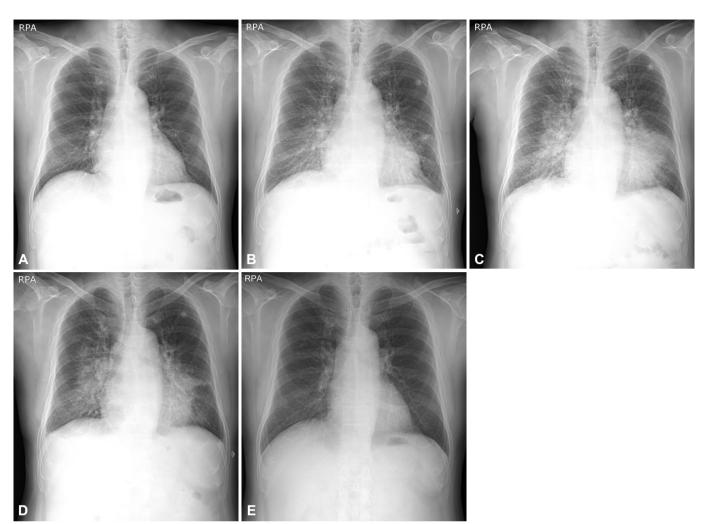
Serial chest radiographs. A: no pulmonary edema at the initial presentation. B: newly appeared bilateral alveolar infiltrates a day after the procedure. C: rather aggravated pulmonary edema despite intravenous furosemide therapy. D: slightly improving the pulmonary edema after initiation of intravenous steroid. E: complete resolution of pulmonary edema at discharge.
